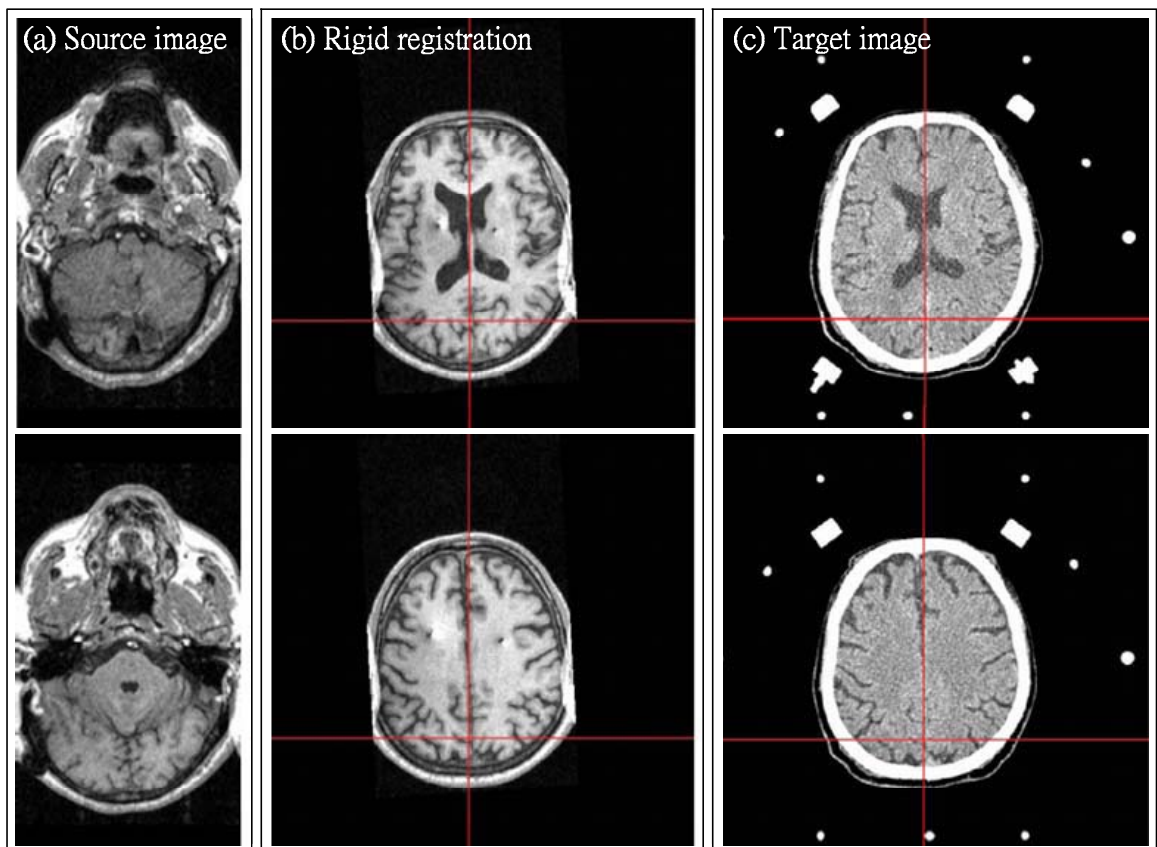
Intra-subject rigid alignment between T1-weighted and CT images using the proposed affine method. (a) T1-weighted image as the source image. (b) Source image after the rigid registration. (c) CT image as the target image. The images were provided by Chang Gung Memorial Hospital.
